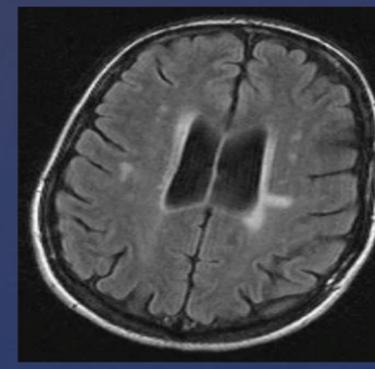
This FLAIR MRI shows the nulled appearance of the usually bright appearance of darkened area of demyelination within the normally bright accentuated myelin.⁴
